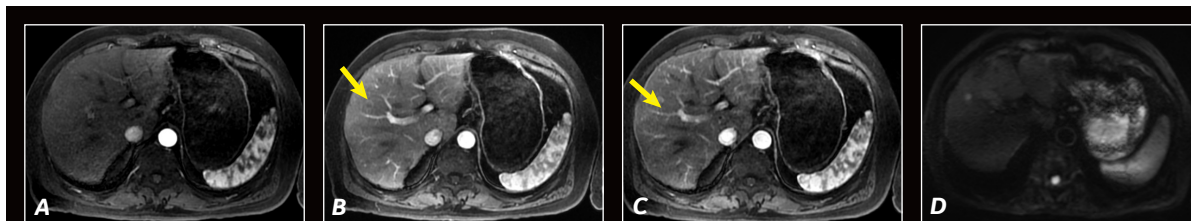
Patient with liver metastases. (A-D) DWI b400, 1.5 x 1.5 x 3.6 mm, 26 sec. for 3 arterial phases, HyperSense factor of 1.3.
